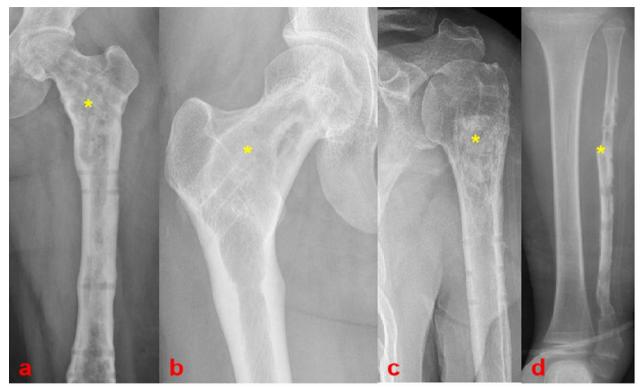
The postoperative X-rays of our cases with removal of internal fixation. A The postoperative anteroposterior X-ray showed bone fusion (yellow asterisk) in a previous lesion site with a radiographically ground-glass appearance for Patient 2. B and C The postoperative anteroposterior X-ray showed removal of internal fixations and bone fusion (yellow asterisk) in previous lesion sites with a radiographically ground-glass appearance for Patient 4 and Patient 5, respectively. D For Patient 7, a strong autogenous fibular bone fused to allogenic fibular bone (yellow asterisk) was observed, and the internal fixation was removed by the surgeon
